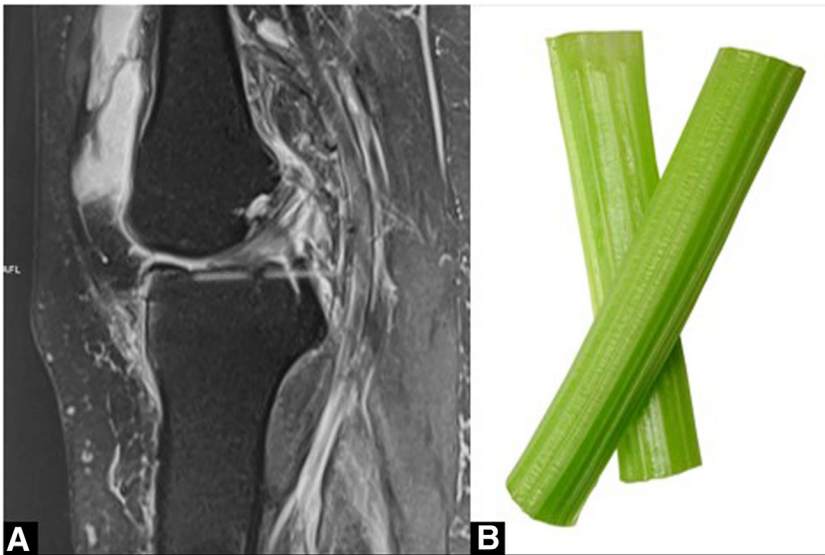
(A) MRI of the left knee. The sagittal T2-weighted PDFS image shows bulky ACL showing celery stalk appearance suggestive of ACL mucoid degeneration. (B) Pictorial representation of the celery stalk. (ACL, anterior cruciate ligament; PDFS, proton density fat saturated.)
